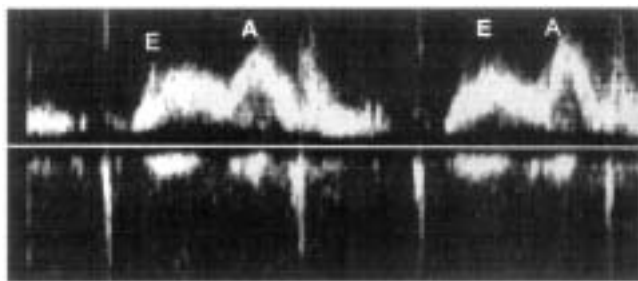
Pulsed-wave Doppler interrogation of the tricuspid valve, demonstrating an impaired transtricuspid flow velocity pattern in a patient with mitral regurgitation. Note the increased peak velocity of atrial contraction wave, the reversal (<1) of the E/A-wave ratio, and the prolonged deceleration time of early filling.
